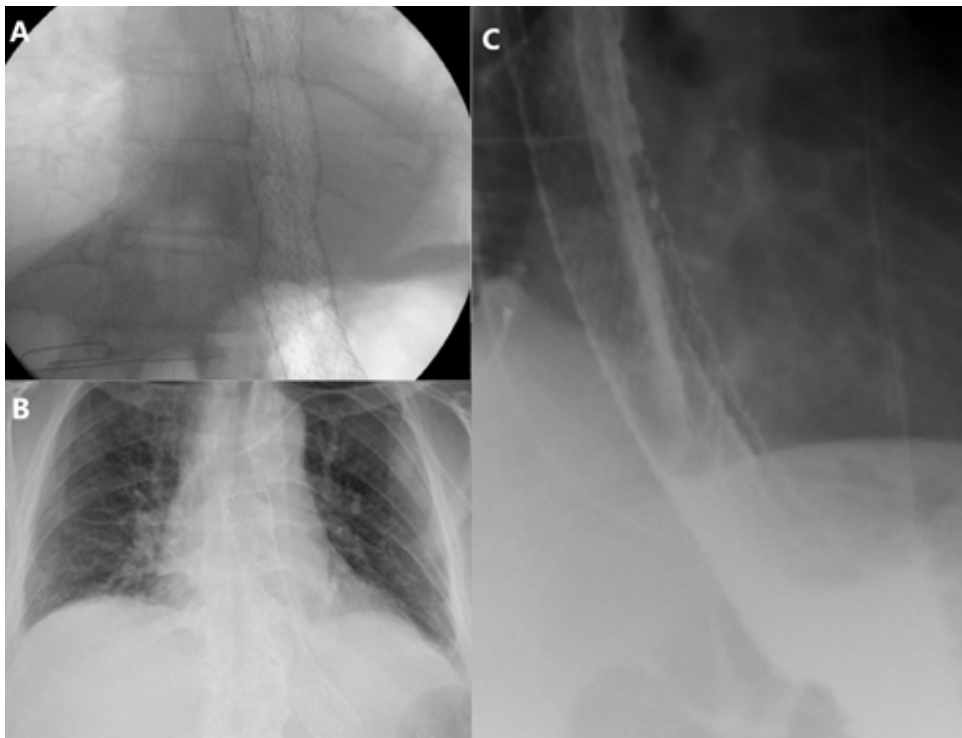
CLOCKWISE FROM LEFT: A-STENT PLACEMENT UNDER FLUOROSCOPIC GUIDANCE, PAPERCLIP DENOTES GASTROESOPHAGEAL JUNCTION; B-CHEST X-RAY ON DAY 13, WITH STENT AND NO RADIOGRAPHIC EVIDENCE OF COVID INFECTION; C- ESOPHAGRAM ON DAY EIGHT.
